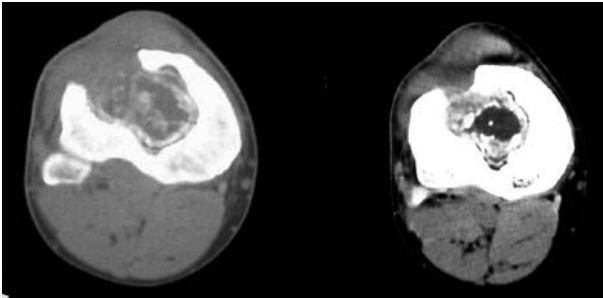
CT-scan right tibia 3 months after surgery.
